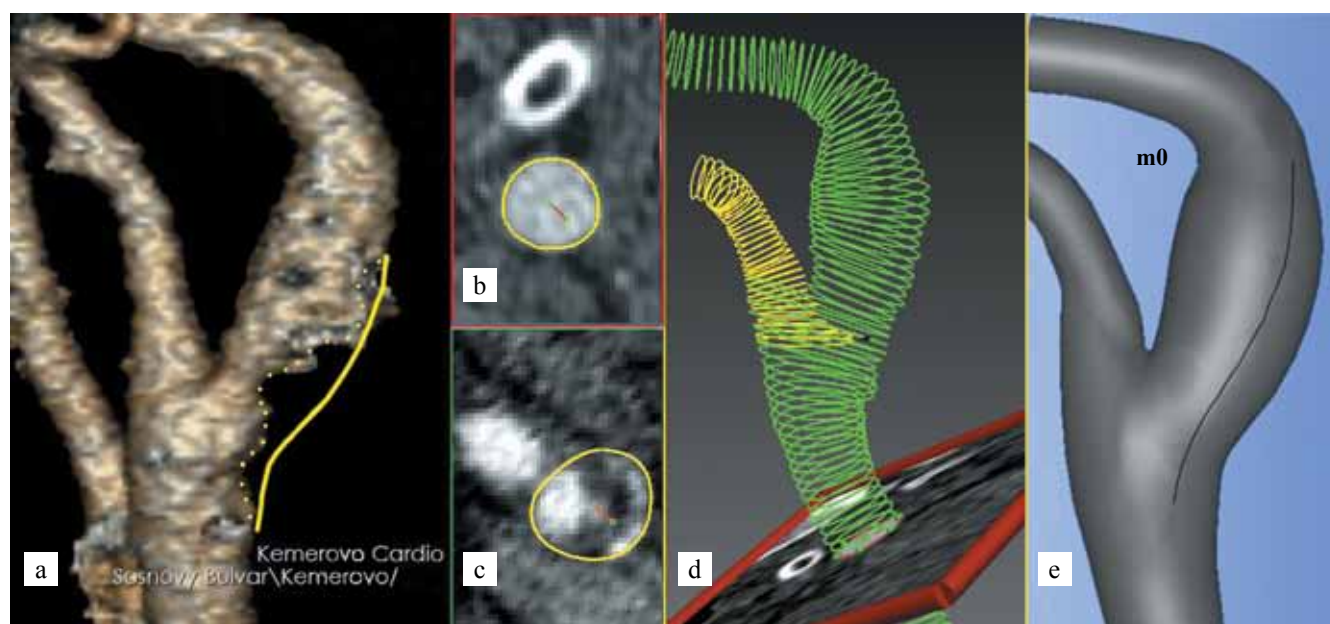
CT angiography of preoperative flow area in carotid arteries (vessel in the foreground). (a) Segmentation contour in the healthy part of the CCA. (b) Segmentation contour in the affected part of the ICA near the bifurcation. (c) CCA-ICA and ECA segmentations. (d) Geometric shape of the base model m_0 with an incision line (e)
